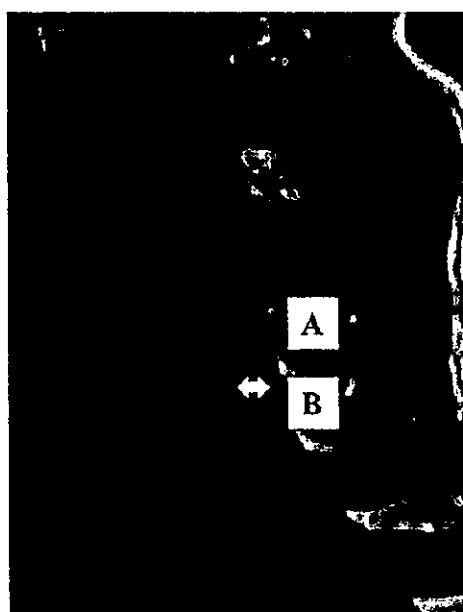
T1-weighted image. Black arrow (A) intact cervical spinal cord. White arrow (B) cervical spinal cord compressed by a disc and ligament flavum. Compression rate was 34%.
